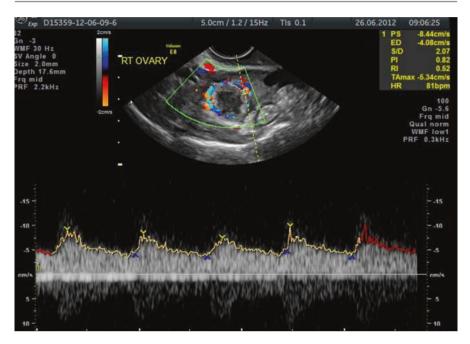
Colour and pulse Doppler of the corpus luteum showing low resistance flow
